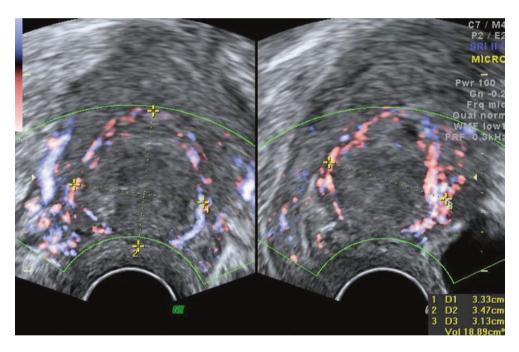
Peripheral flow seen on Doppler around a fibroid
